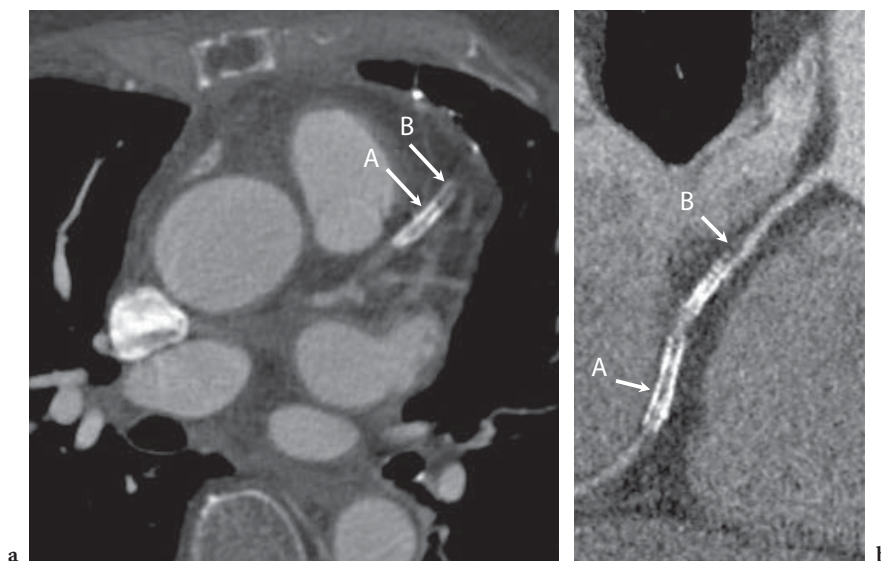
a Patient investigated with 64-slice CT. A thrombus clot is seen in the left anterior descending coronary artery within (arrow A) and distal (arrow B) to the stent. b Another patient with in-stent (arrow A) and pre-stent (arrow B) stenoses in the right coronary artery
